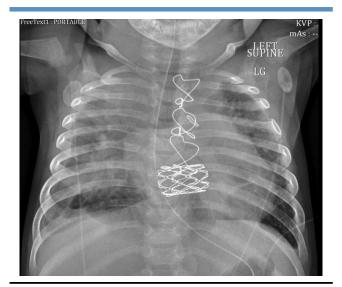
Chest radiograph of a 9 month-old-male patient with a history of trisomy 21, obstructive sleep apnea, tetralogy of Fallot, pulmonary vascular hypertension, and right dominant atrioventricular canal with parachute left AV valve who had surgical repair at 3 months of age with the placement of Melody valve in the left AV valve position obtained on hospital day 2 at time of transfer to the cardiac intensive care unit with increased airspace opacification in the right upper lobe along with increased right pleural effusion apically and laterally. Persistent perihilar and lower lobe opacities are also noted.
